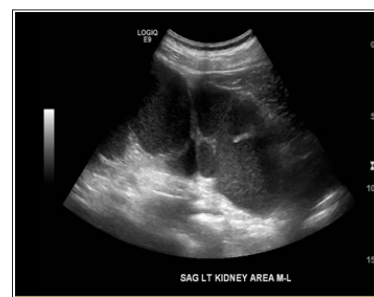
Renal ultrasound showing severe chronic left sided hydronephrosis.
